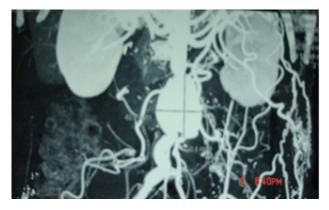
Contrast enhanced computed tomography showed false aneurysm at the proximal anastomosis post Aorto- bi-iliacal bypass in a patient with Aorto- duodenal fistula.
